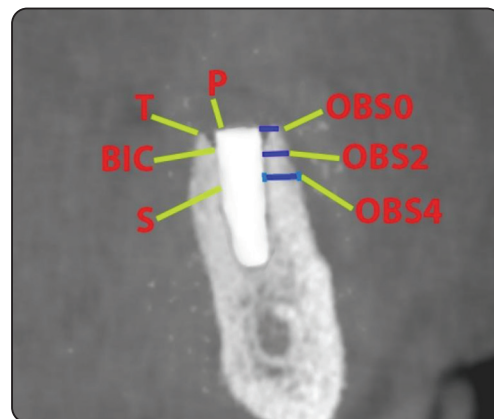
Measurement of vertical and horizontal alveolar bone changes on the crosssectional images of the CBCT.
